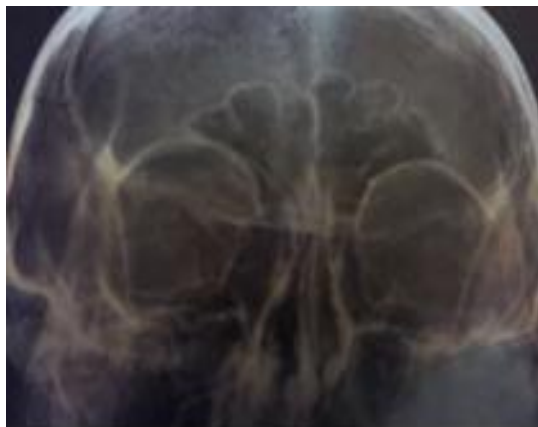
Orbital radiography : normal
